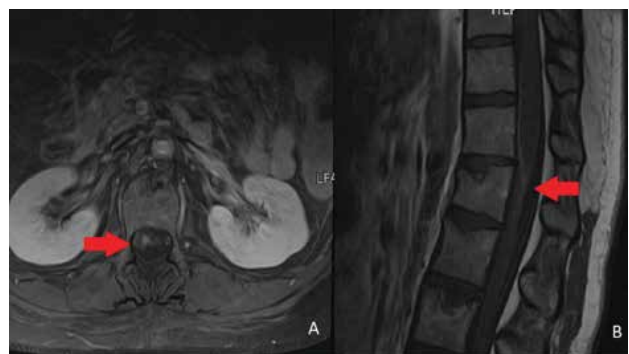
MRI lumbosacral spine showing enhancement of the conus medullaris and cauda equina nerve roots.
